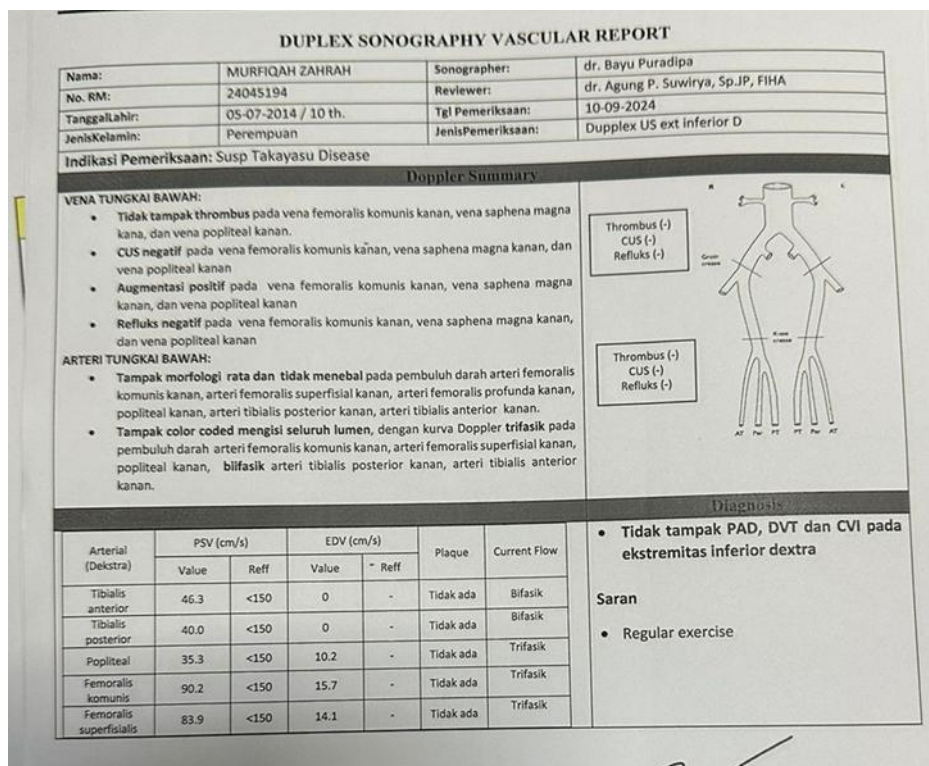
Duplex Sonography Vascular Right Inferior Extremity Examination Results
